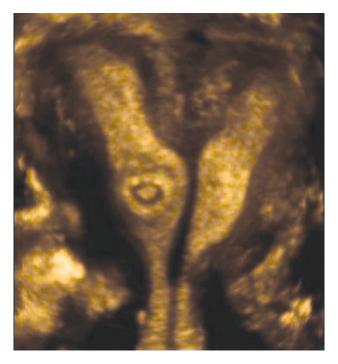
A singleton pregnancy in a didelphic uterus. Three-dimensional sonographic examination of a malformed uterus provides the sonographer with an accurate classification of the uterine anomaly and pregnancy number. For this purpose a coronal section is important because it provides visualization of the fundal region and length of the septum
